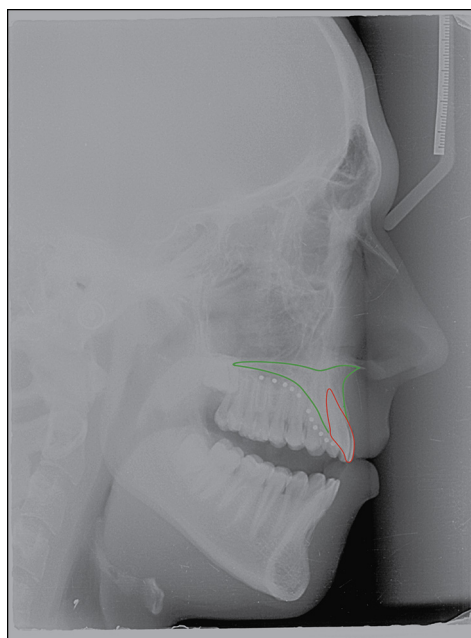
Cephalometric radiograph showing palatal reference points.
